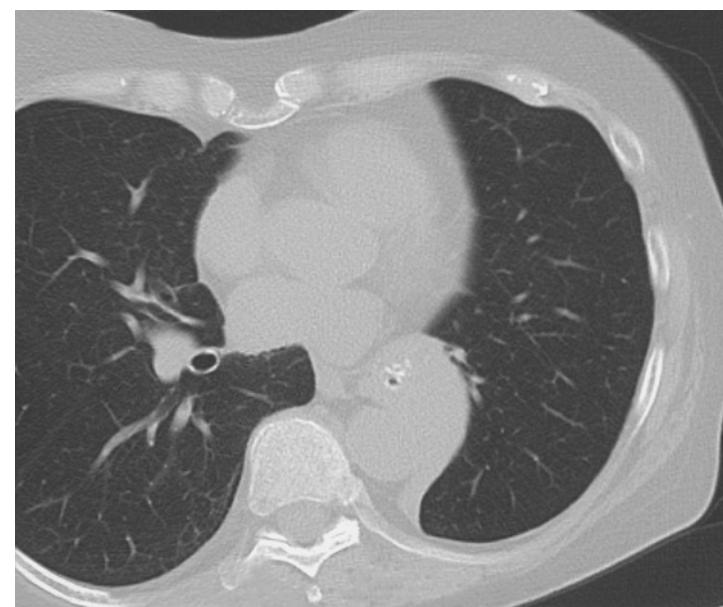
The “S” sign on CT. The image shows a mass along the left lower lobar bronchus with lower lobar atelectasis peripheral to it. The walls of the segmental bronchi are calcified within the tumor. The left upper lobe shows compensatory emphysema.
